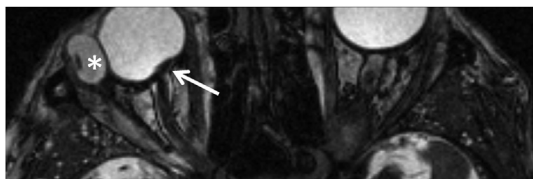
Magnetic Resonance Imaging; Axial 3D T2W FastFieldEcho image. Impression of the dislocated hypointense silicone encircling band on the optic nerve nasally inferior (arrow). Swollen hydrogel explant on the temporal side of the right eye visible as an oval hyperintense structure with minimal impression on the eye (asterix).
